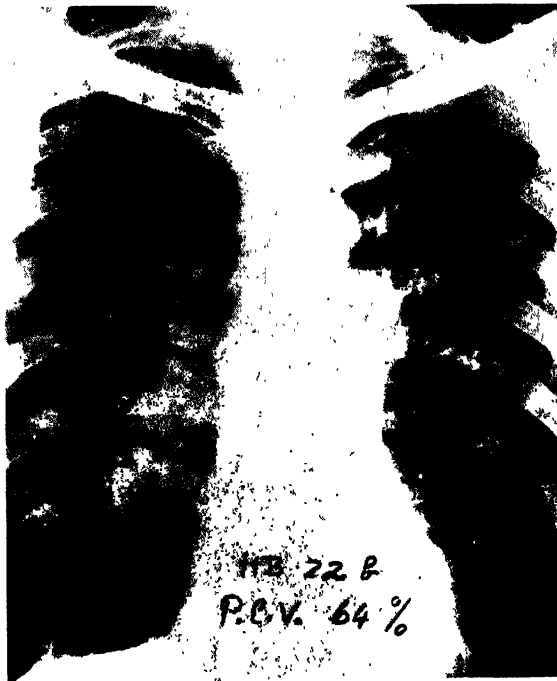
Case 42. Emphysema complicated by polycythaemia; heart failure. Radiograph 6 years earlier showed evidence of widespread emphysema. Now heart, hilar vessels and some lung vessels larger. Cough, sputum and increasing dyspnoea. Hb 22 Gm. PCV 64%, right ventricular hypertrophy. Emphysema panacinar Grade III and IV.
